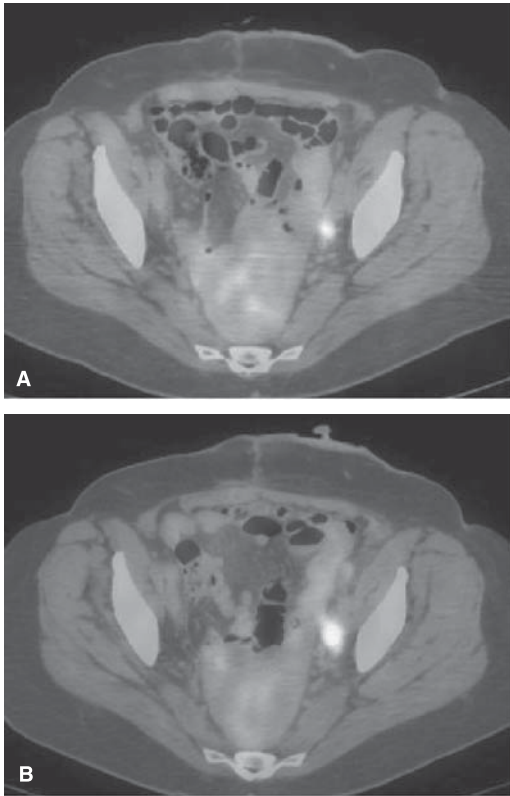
(A) Focal intense radiotracer uptake in a subcentimeter left pelvic side wall lymph node is consistent with metastasis. (B) Axial fusion PET/CT image in the same patient 3 months later demonstrates enlargement of the same pelvic side wall lymph node.
